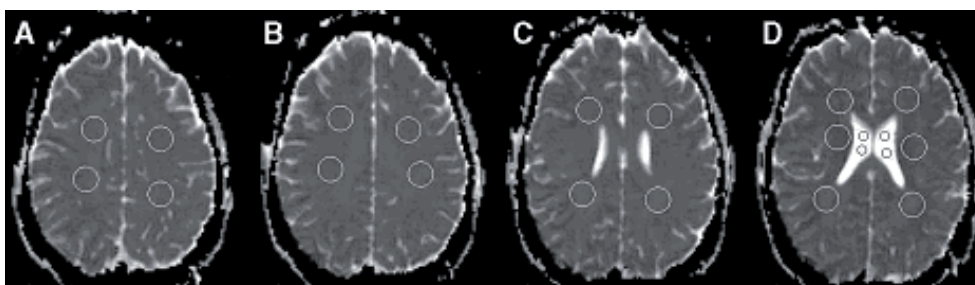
Axial T2-weighted MR images show the 22 regions of interest. Slice A placed above slice B, and slices C and D placed at the level of the cella media of the lateral ventricles.
